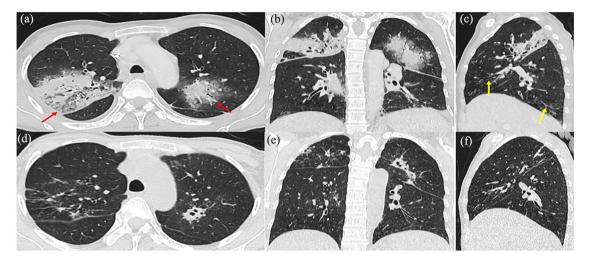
CT chest of a 52-year-old lady. (a–c) CT at the time of admission. (a) Axial, (b) coronal, (c) sagittal images showing multifocal areas of consolidation with surrounding halo of ground glass attenuation (red arrows). Focal bronchiolectasis is also evident in lingular and posterior basal segments (yellow arrows) due to previous infections. (d–f) CT after 14 days of voriconazole therapy. Significant resolution of consolidations is seen with small areas of cavitation in left upper lobe. CT, computed tomography.
